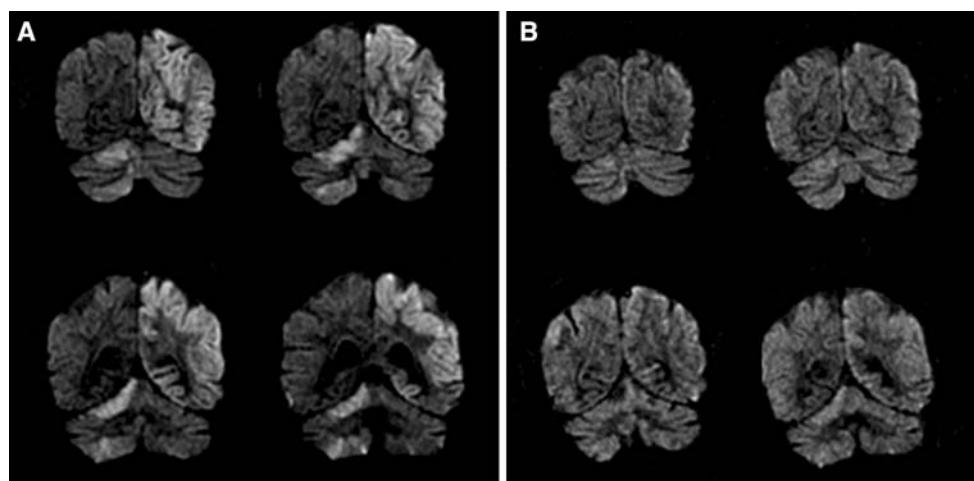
Coronal diffusion-weighted MRI demonstrating extensive areas with reduced diffusion in the left temporo-parietal cortex and the right cerebellum (a). Interval near-complete resolution of seizure-related diffusion changes after 2 weeks (b)
